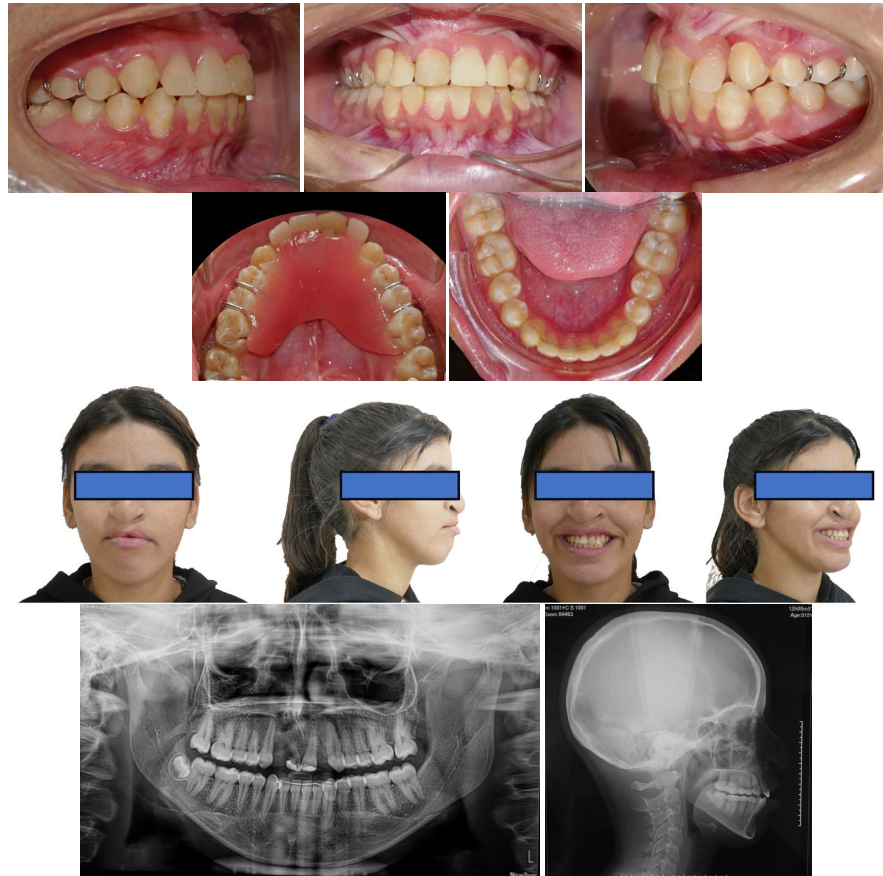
Photographs and X-rays at end of treatment.
